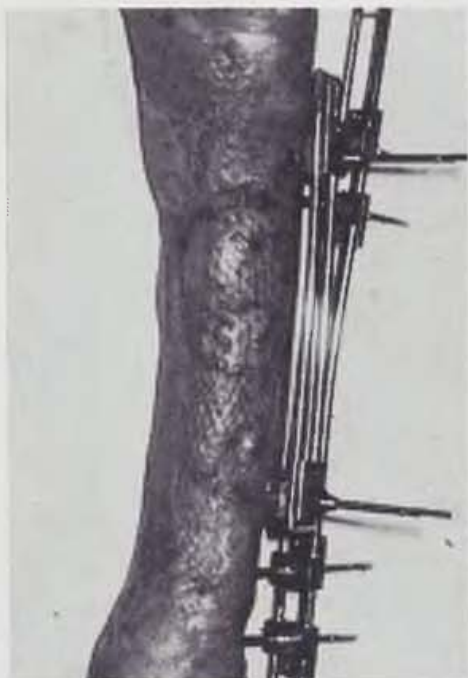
Status after healing. — Fig. 8. X-ray after healing of soft tissues prior to spongioplasty.
